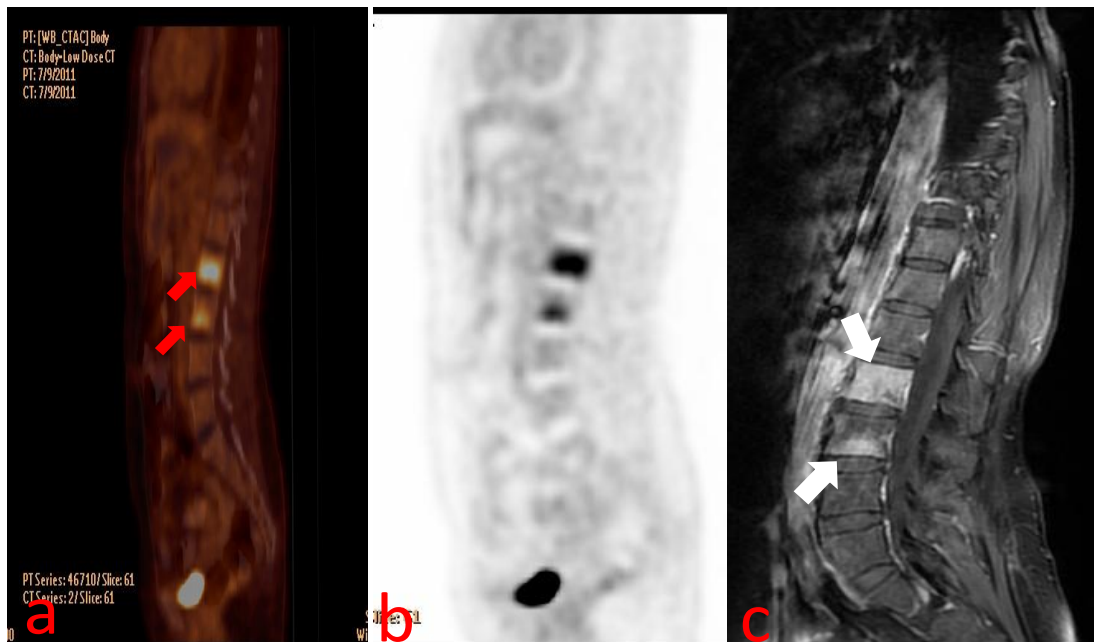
A 48-year-old patient, known case of double malignancies in tongue SCC and rectal cancer post surgery and chemo-RT, recently complained of low back pain. 18F FDG PET/CT showed FDG avid hypodense osseous lesions in L2 and L3 vertebrae (red arrows) on the sagittal fused FDG PET/CT (a) and FDG PET (b) images. Post contrast lumbar spines CT showed enhanced lesions in L2 and L3 (white arrows). Biopsy was taken from these lesions and proved to be metastatic SCC.
